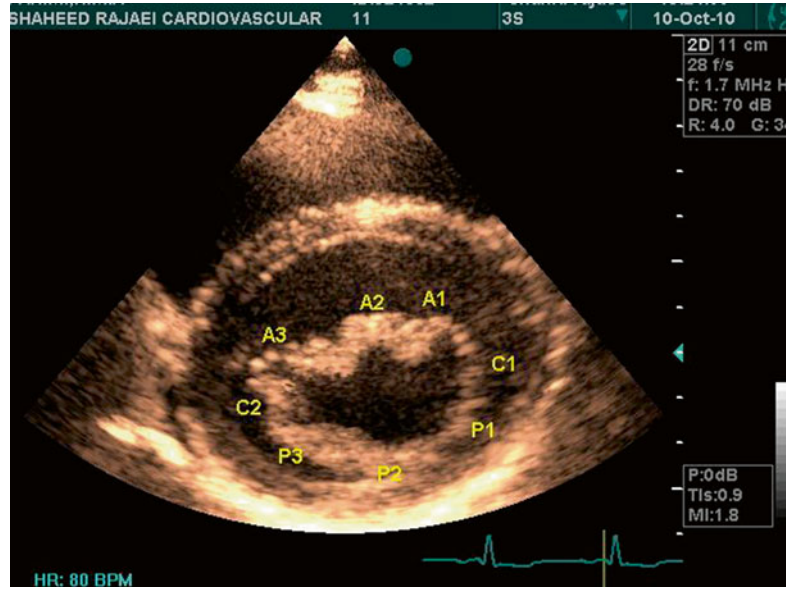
Short-axis view of the mitral valve, demonstrating the mitral valve scallops in two-dimensional transesophageal echocardiography. *A1* anterolateral scallop, *A2* anteromiddle scallop, *A3* anteromedial scallop, *P1* posterolateral scallop, *P2* posteromiddle scallop, *P3* posteromedial scallop, *C1* lateral commissure, *C2* medial commissure
